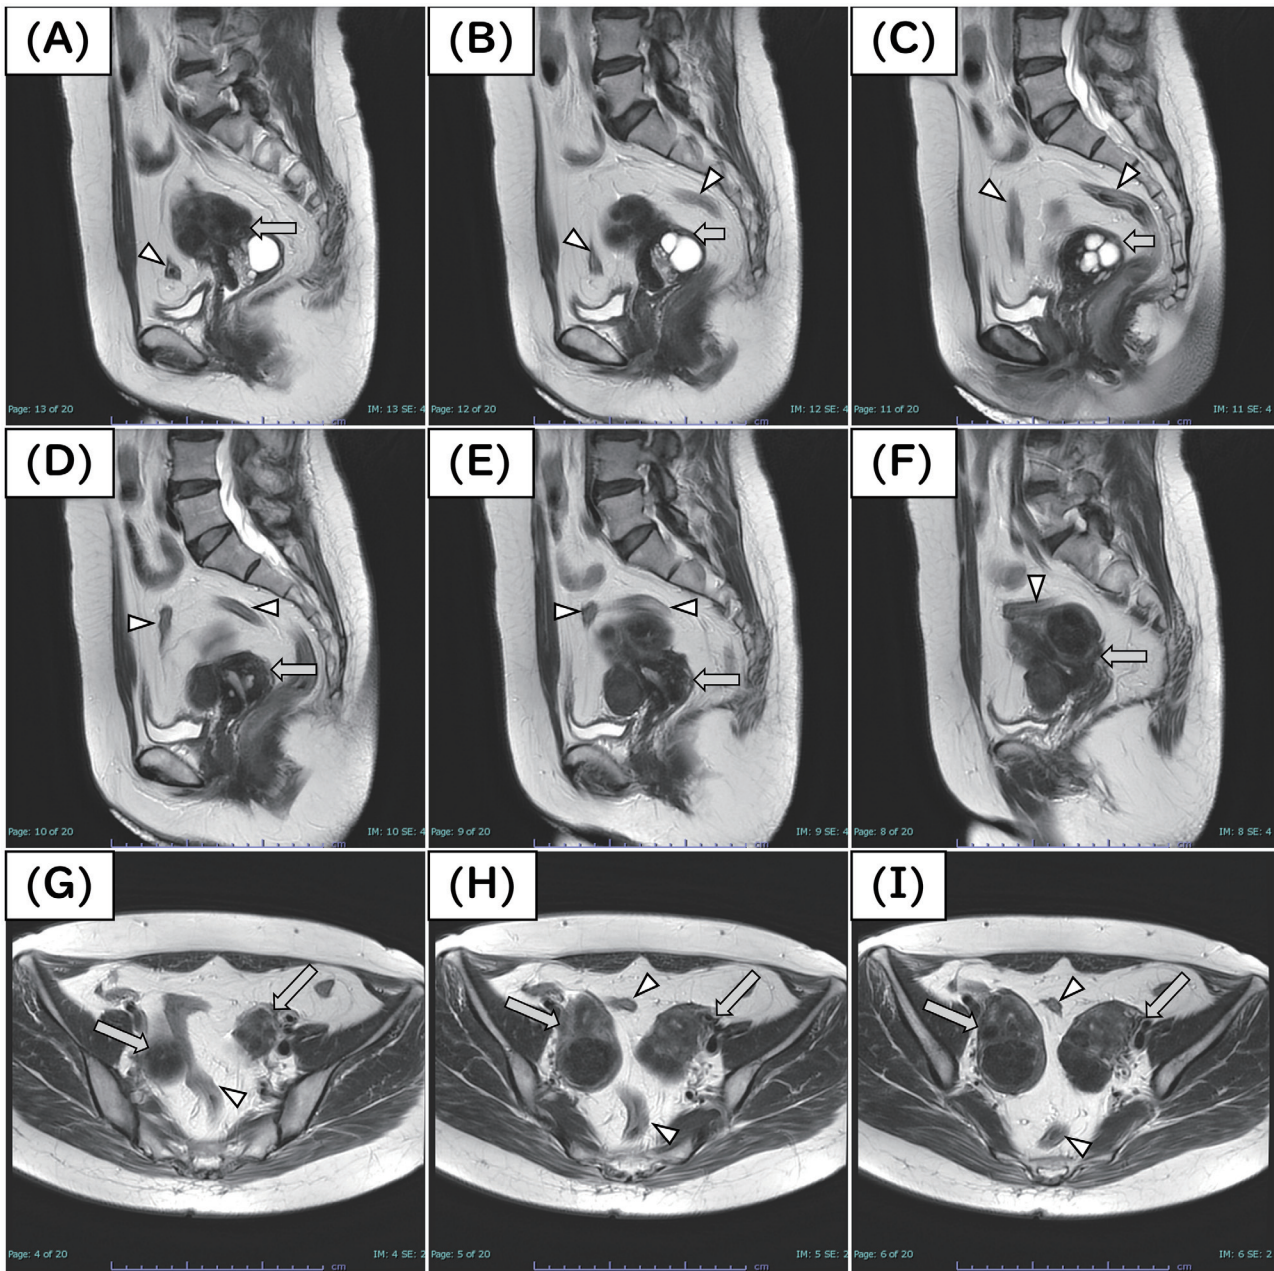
MR images (A)–(F): Sagittal section (left to right), (G)–(I): axial section (cranial to caudal). Arrow, uterus; arrow head, sigmoid colon.
